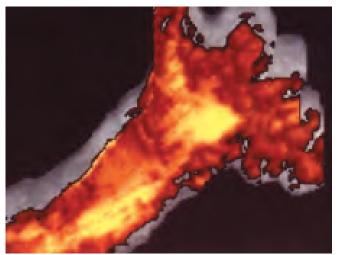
Regular spillage of the contrast medium following 3D power Doppler Hy-Co-Sy
